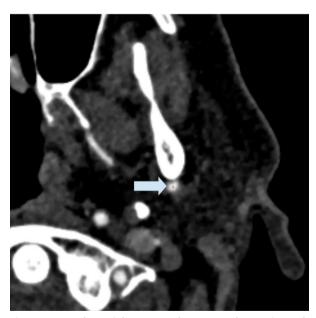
In the axial computed tomography angiograph image, the arrow shows the small red circle which marks the artery's nearest point to the surface of the condyle (in contact with the posterior surface of the mandibular condyle).
